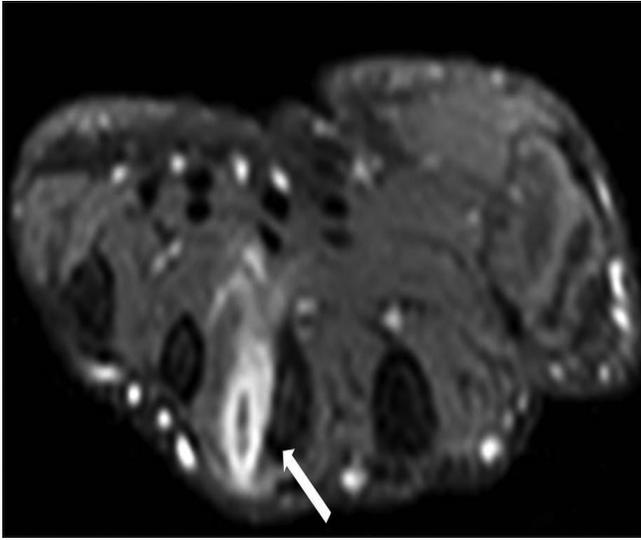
MRI -T1fat- saturated post contrast image-showing peripheral ring enhancement (arrow) and causing scalloping of the adjacent 3rd metacarpal.
